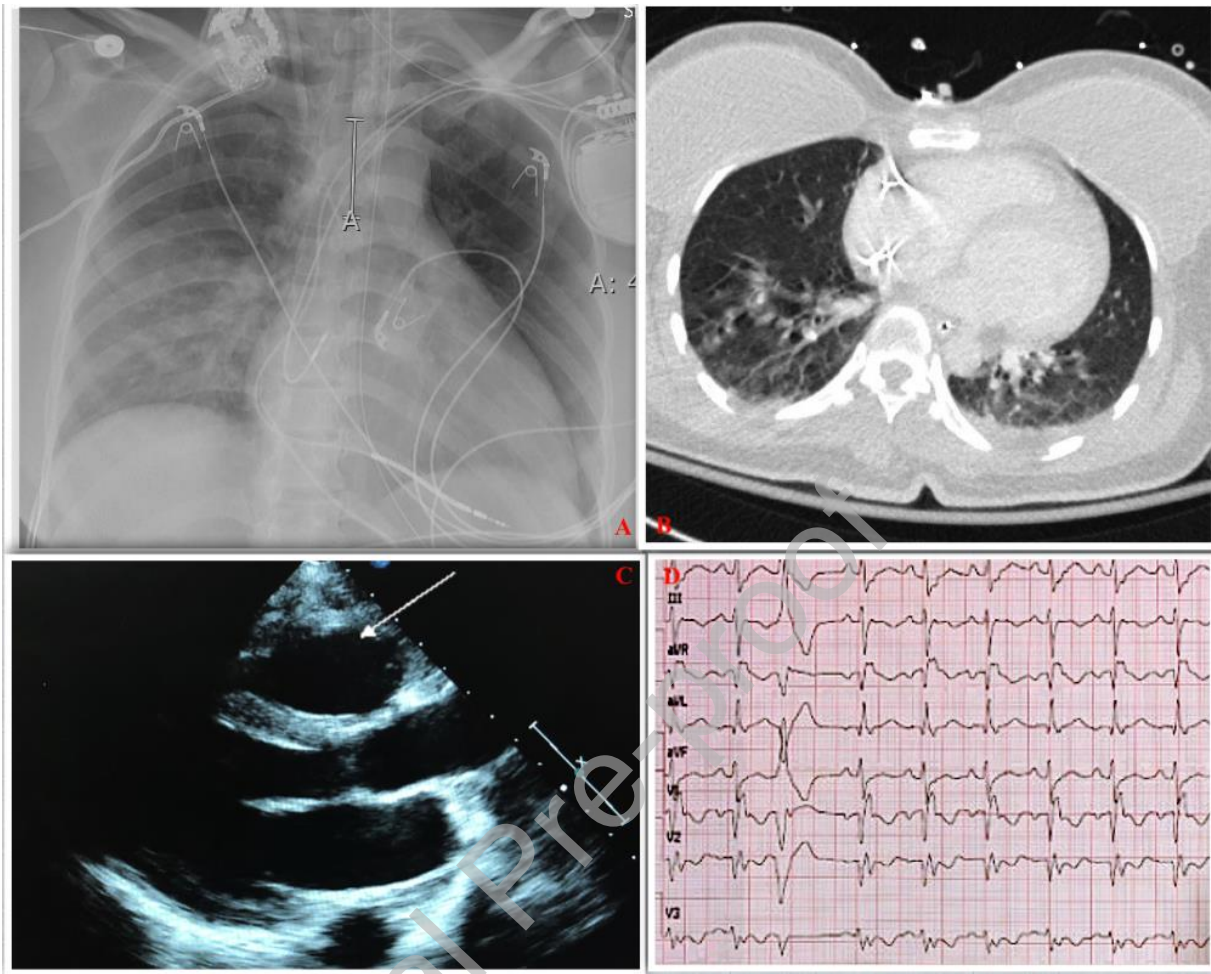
(A) Chest X-ray image showing mild pulmonary venous congestion with interstitial opacities in the right perihilar and right lower lobe. (B) Computed tomography of the chest notable for multiple nodules throughout the right lower lobe. (C) Parasternal long-axis view. Arrow points to dilated right ventricle. (D) Inverted T waves in leads V1, V2, V3, and V4 in the presence of complete right bundle branch block.
